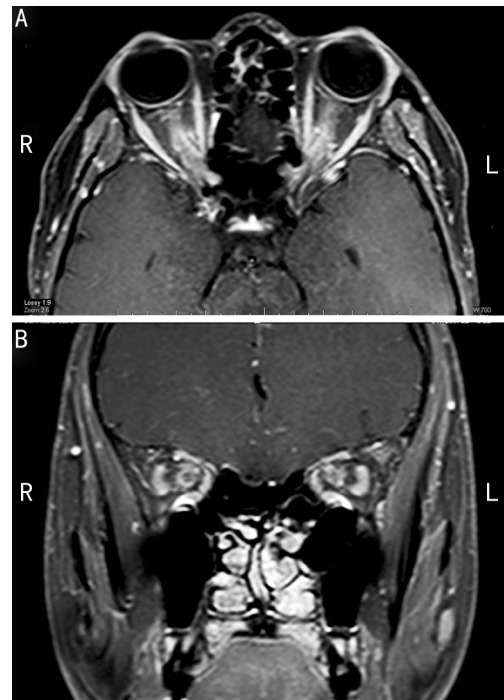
Contrast-enhanced MR images showing marked enhancement of the optic nerve sheath on A: Axial view (tram track sign); B: Coronal view (doughnut sign).
